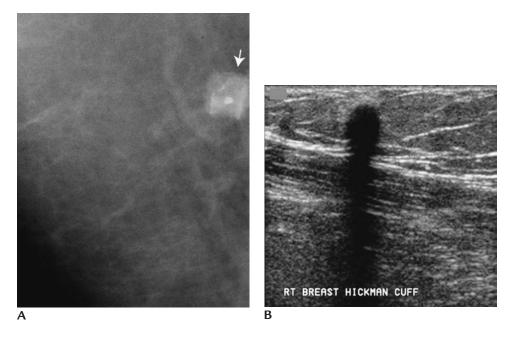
Hickman catheter Dacron cuff. (A) As they age, the cuff (*arrow*) can increase in density and become frayed and some calcify. Typically these are identified in the upper inner quadrants and may be palpable. (B) Ultrasound demonstrating intense shadowing at palpable cuff site.
